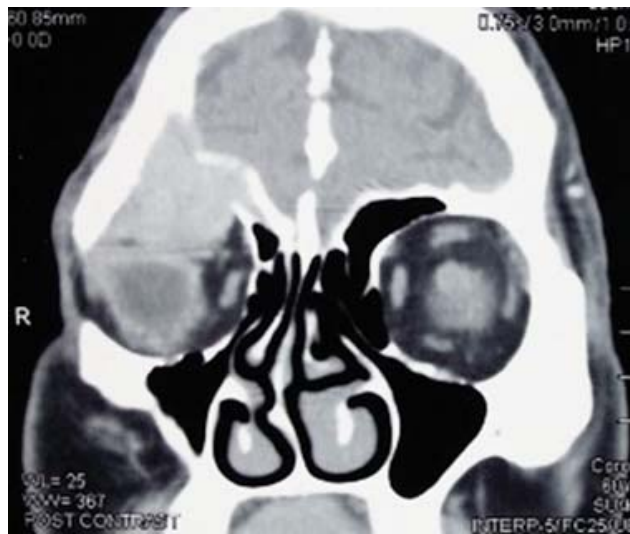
Computed tomography (CT) scan showing the coronal view of a metastatic lung cancer mainly involving the roof of the right orbit and extending onto lateral and medial walls. Erosion of orbital roof is also present.
